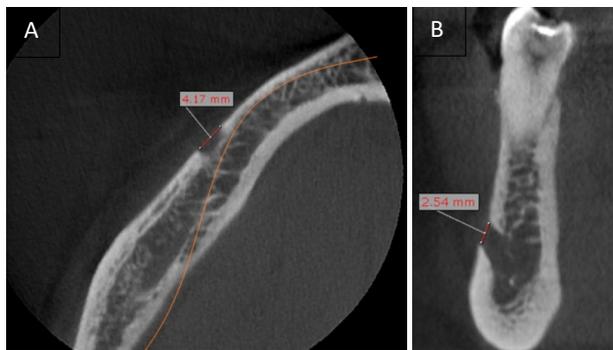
Axial image (A) and coronal oblique multiplanar reconstruction image (B) of CBCT scan show the width (4.17 mm) and height (2.54 mm) of MF, respectively.
